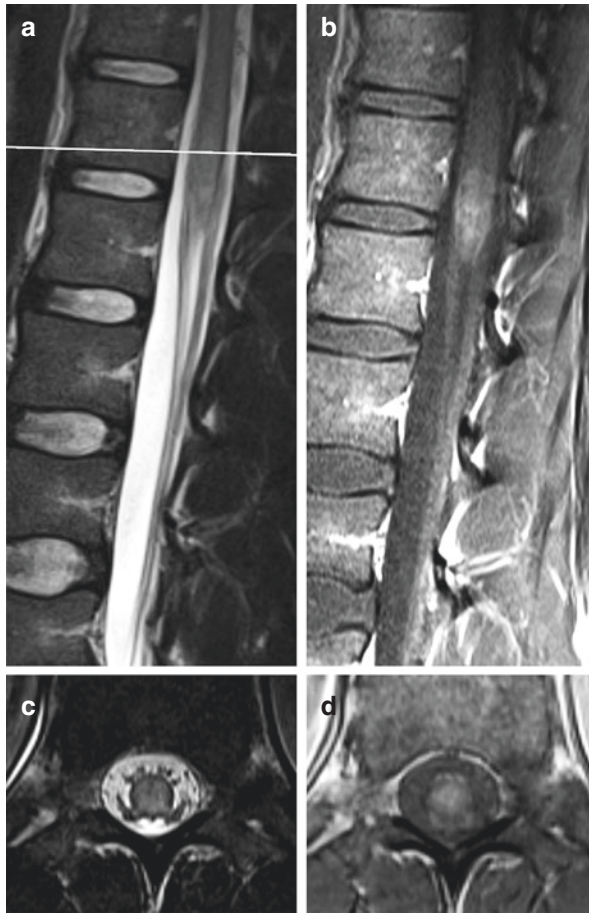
Schistosomiasis. A 24-year-old male Brazilian student was visiting Germany when developing a conus/cauda syndrome. The spinal MRI shows a longitudinal myelitis with predominant involvement of the conus medullaris with patchy gadolinium enhancement. Diagnosis of schistosomiasis was based on positive *Schistosomiasis mansoni* antibody testing. A full recovery was achieved by treatment with praziquantel. (a, c) T2w-TSE images, (c, d) T1w-SE images with gadolinium (Images courtesy of Dr. Peter Raab, Neuroradiology, Hannover Medical School)
